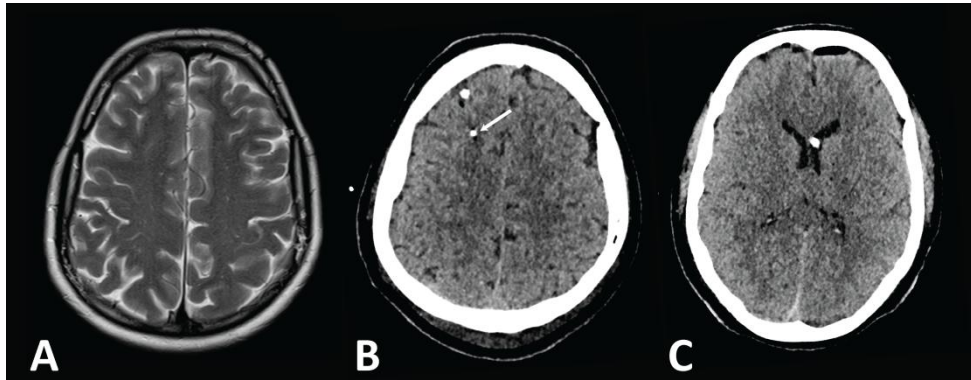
Example of the placement of a cerebral microdialysis MD probe and an external ventricular catheter. The MD catheter has a gold tip that makes it visible on a computed tomography (CT) scan and thus allowing the determination of the exact position of the probe (arrow). A 38-year-old female received an operation for a glial cyst in the right cerebellar tonsil. A. Preoperative T2W MRI slice shows a normal signal in the zone in which the MD probe was inserted. B. Control CT scan performed the day after surgery. The tip of the MD probe is shown (arrow). C. The ventricular catheter is seen entering into the left frontal horn in the control CT scan.
